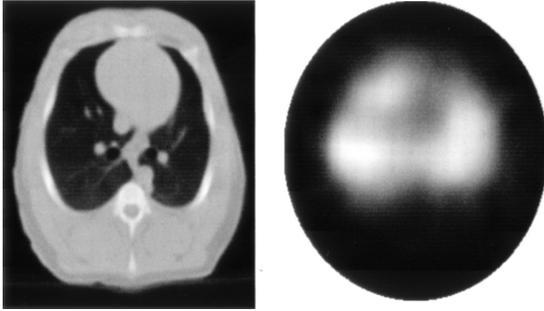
Conventional computed tomogram (left) versus image created with electrical impedance tomography (EIT). EIT allows intensive-care-unit imaging of the lung, and the EIT image allows identification of atelectatic and aerated lung regions. The images are created in a single cross-sectional plane by computer reconstruction of electrical impedance readings across an array of electrodes wrapped around the chest. The image on the left is a conventional computed tomogram slice and the image on the right is an EIT cross-sectional image of the same slice. The aerated regions on the EIT image are white and the heart shadow is dark. (From Reference 34, with permission.)
